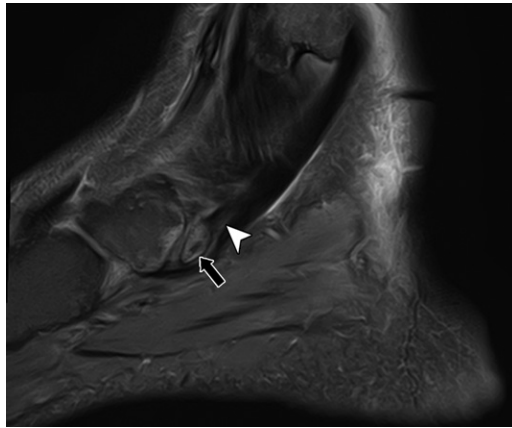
Symptomatic accessory navicular bone in a 39-year-old woman with long-standing focal pain at the medial navicular bone. Sagittal fat-suppressed T2-weighted MR image shows a triangular ossicle (arrow) with its base closely apposed to the navicular bone, which is typical of a type II accessory navicular bone. There is marrow edema in the ossicle and adjacent navicular bone, mild regional inflammation, and altered signal intensity in the terminal fibers of the PTT near its insertion (arrowhead). Note that the PTT inserts predominantly onto the ossicle rather than the more distal navicular bone, altering its mechanics.
